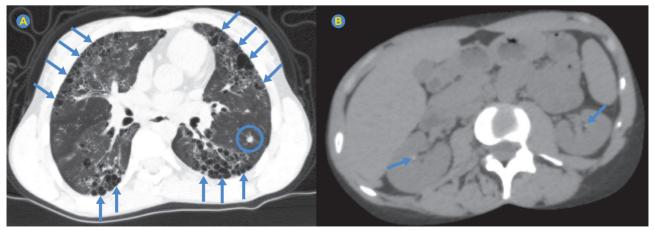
Axial section of the patient's computed tomography (lung window), revealing multiple pulmonary cysts (arrows) and a nodule in the left lung (circle) (A). Abdominal computed tomography of the patient, demonstrating nephrolithiasis in both kidneys (arrows) (B).
